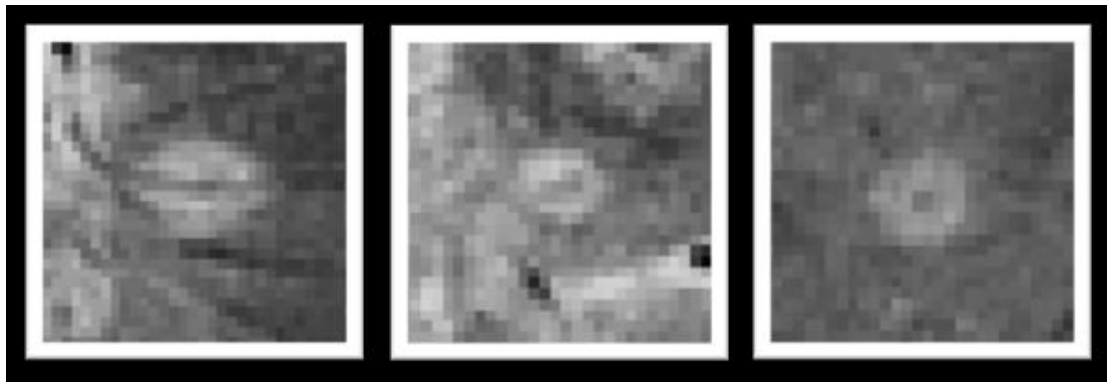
Examples of lesions detected using optimised 3T T2*-weighted MRI
